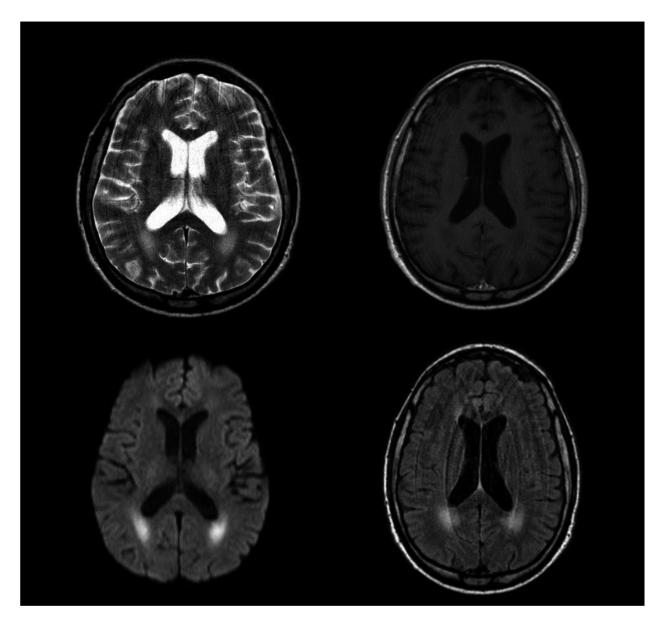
MRI of brain. Axial T2 (upper left), DWI (lower left), and FLAIR (lower right), showing posterior periventricular high signal areas. Axial T1 with contrast medium (upper right) showing no enhancement.
